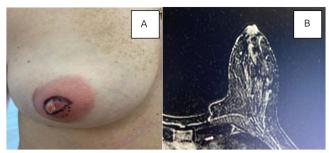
(A) Lesion in the right nipple affecting more than half of its volume and (B) MRI showing enhancement within the right nipple.
